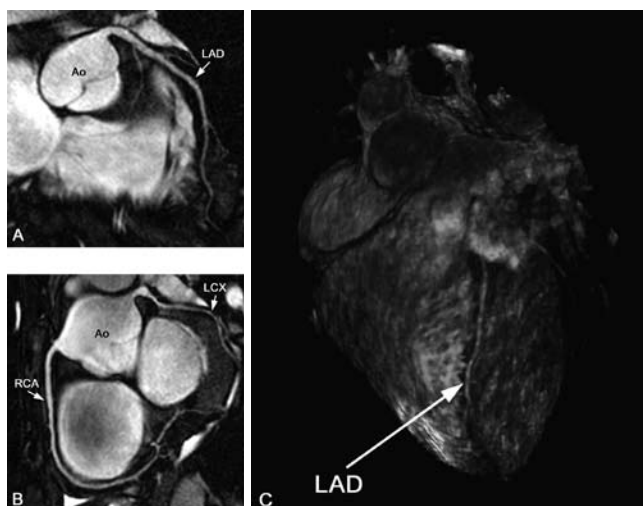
(A) Targeted images of the left anterior descending artery (LAD), (B) right coronary artery (RCA) and (C) whole-heart scan in healthy volunteers. With the targeted approach, high-resolution images of the coronary arteries and some branches can be obtained in a relatively short scan time. By using a whole-heart approach, all coronary arteries are imaged in one scan, and the data set allows for post-processing and display of anatomy similar to multi-detector computed tomography. LCX: left circumflex artery, Ao: aorta.
